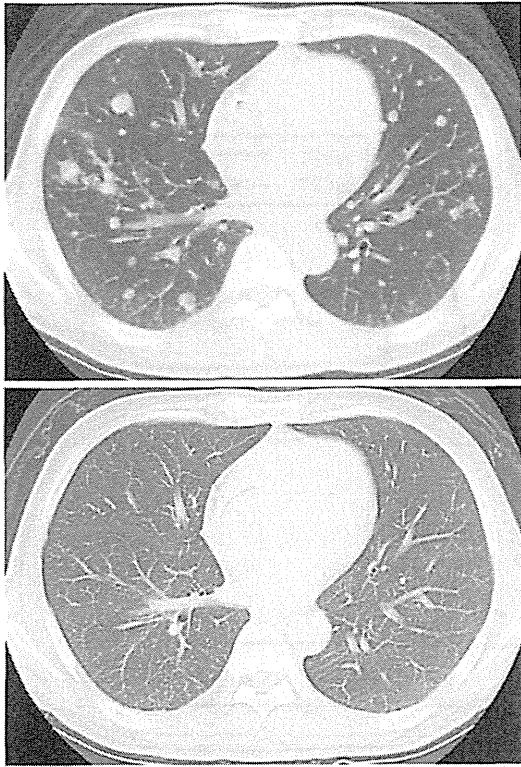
Changes in the chest computed tomography (CT) findings. Upper chest CT showed multiple metastases in the lungs before the initiation of sorafenib administration. Lower chest CT revealed that metastasis was no longer present in the lungs following treatment.
